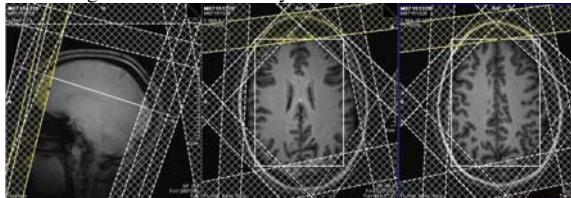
Automatic sat bands placement based on segmented T1-weighted MRI
